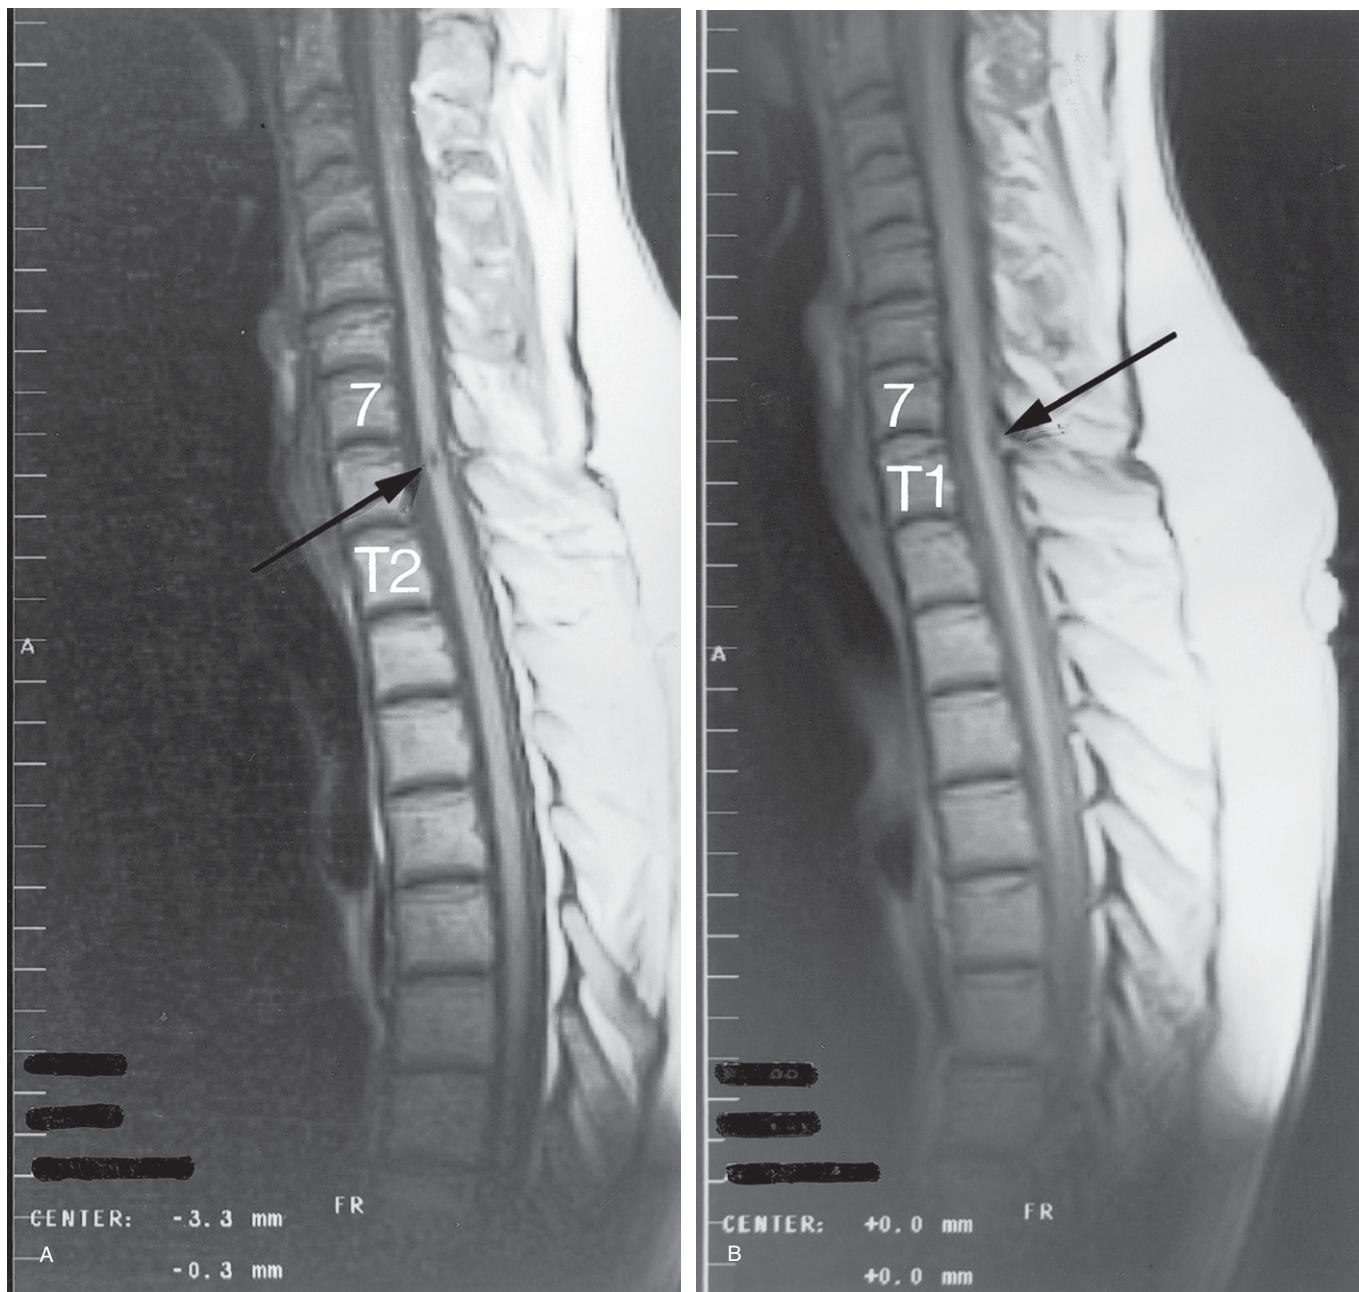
(A) Thoracic spine MRI sagittal T1-weighted image showing the small post-traumatic syrinx at the T1 level (arrow) which indicates an injury to the spinal cord itself. A = anterior; T2 = second thoracic vertebra; 7 = seventh cervical vertebra. (B) Thoracic spine MRI sagittal T1-weighted image showing the effacement of the posterior aspect of the dural tube and the thoracic spinal cord at this level (arrow). A = anterior; T1 = first thoracic vertebra; 7 = seventh cervical vertebra.
